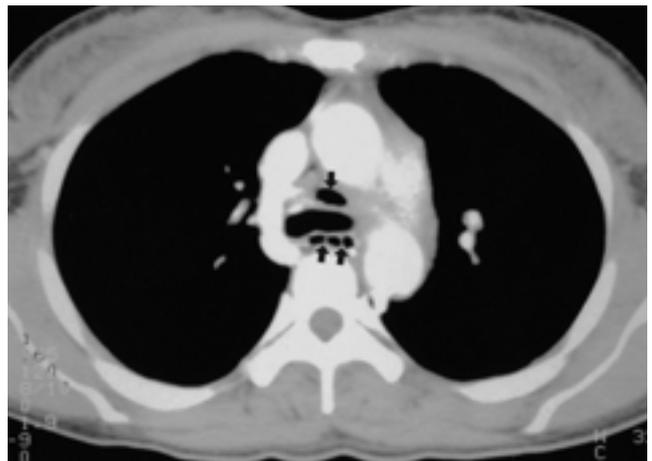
Esophageal perforation due to foreign body in a 38-year-old woman. CT scan at carinal level shows small amount of extraluminal air around airway and esophagus (arrows). Predicted perforation site was lower esophagus and confirmed by esophagography (not shown).
